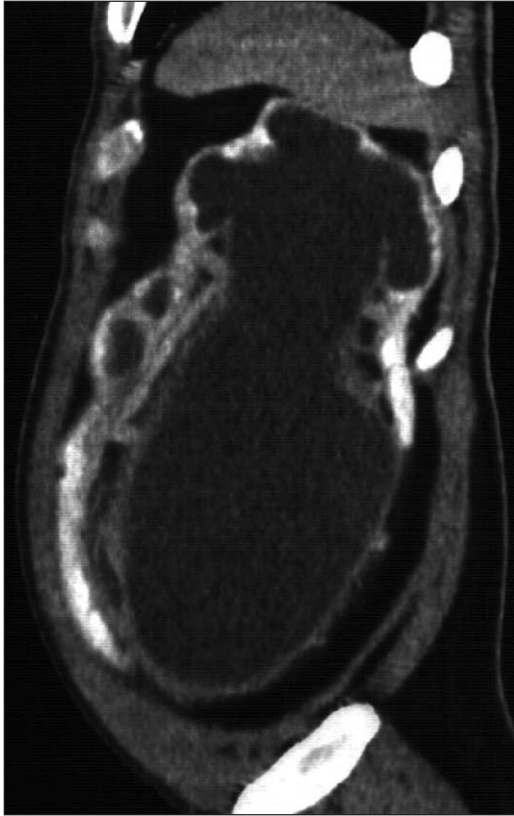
Sagittal CT image of extremely enlarged left kidney with enormous dilated collecting system and considerably reduced parenchyma that shows signs of secretion
